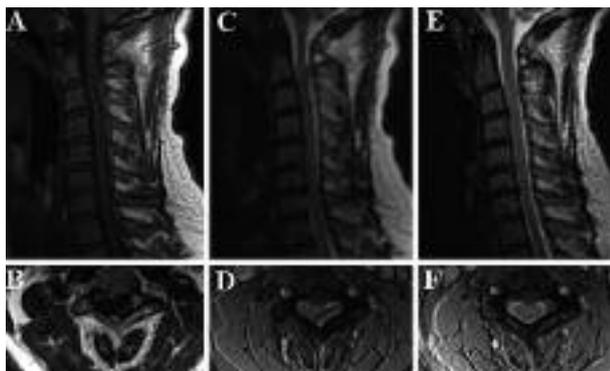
T1-weighted sagittal (A) and axial (B) and T2-weighted sagittal (C) and axial (D) MR images one day after the onset of the symptomatology: a left epidural posterolateral haematoma is shown displacing the spinal cord.
